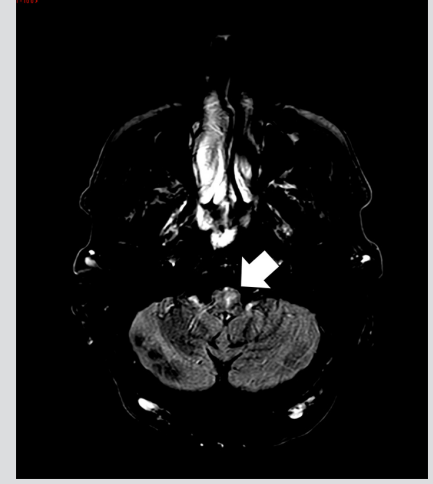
T2 FLAIR MRI image showing an acute infarct (white arrowhead) in the midline medulla and left pyramid
